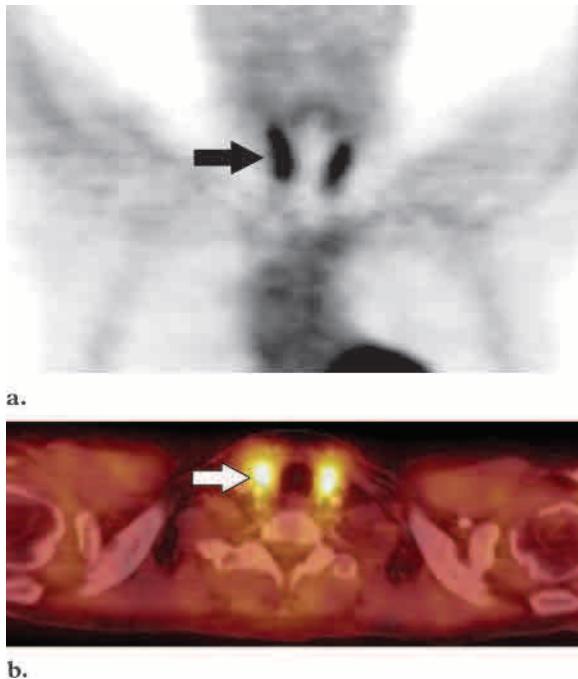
Physiologic thyroid uptake. (a) Coronal PET scan shows diffuse symmetric FDG uptake localized to the thyroid gland (arrow). (b) Axial fused PET-CT scan helps confirm localization of the uptake to the thyroid gland (arrow).
